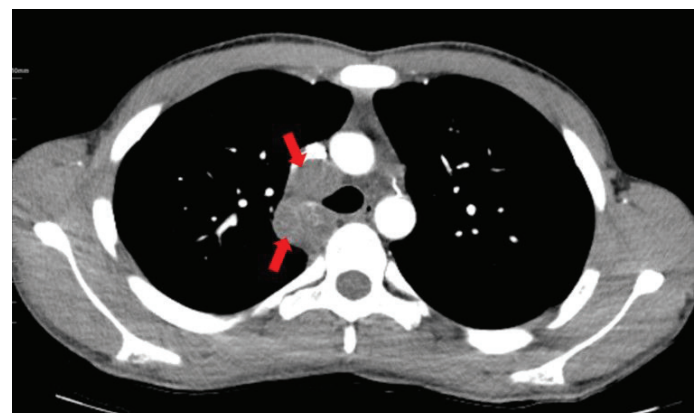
Contrast-enhanced axial thoracic computed tomography (CT) image shows several lymphadenopathies in the right paratracheal area, the largest of which is 32x31 mm in size, showing heterogeneous contrast enhancement (red arrows).
